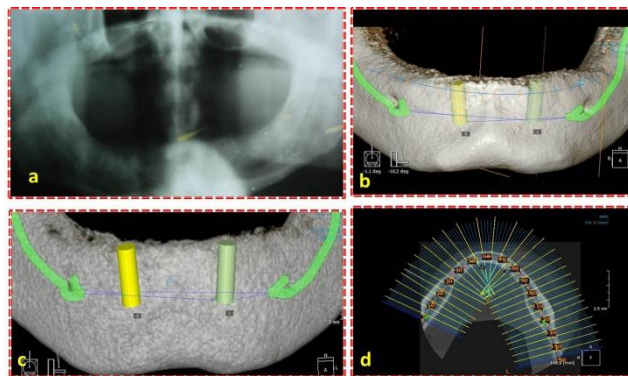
(a) Orthopantomograph showing resorbed mandibular ridge (b) and (c) CBCT analysis and probable location of the implants (d) CBCT showing an occlusal analysis of the ridge to determine the width of the implant
